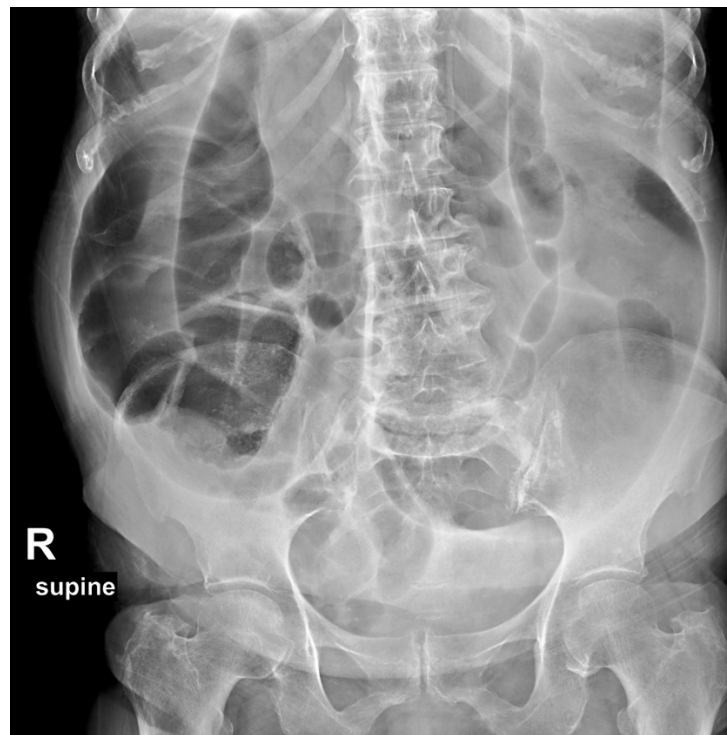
Abdominal X-ray confirmed cecal dilation, approximately 16 cm in diameter
